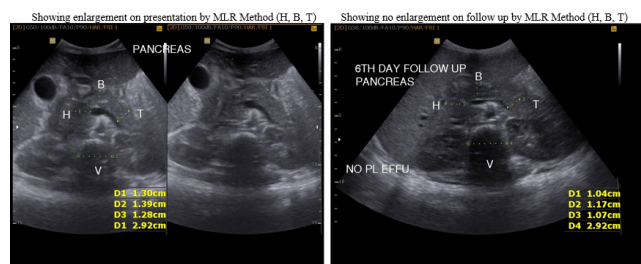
Ultrasonography images showing pancreas at diagnosis and after 6 days upon clinical recovery for a sample patient - in 4.5 years male.
